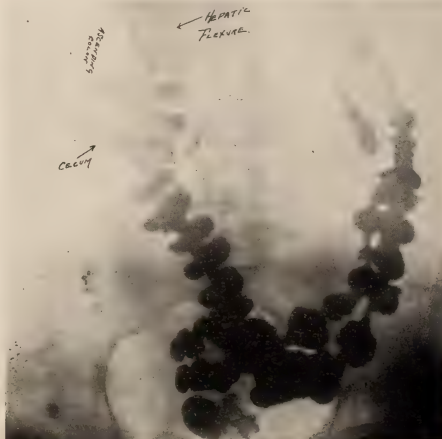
High situation of cecum and hepatic flexure. Short ascending colon. Roentgenological diagnosis of appendicitis verified. Previous diagnosis was gall-bladder disease.
